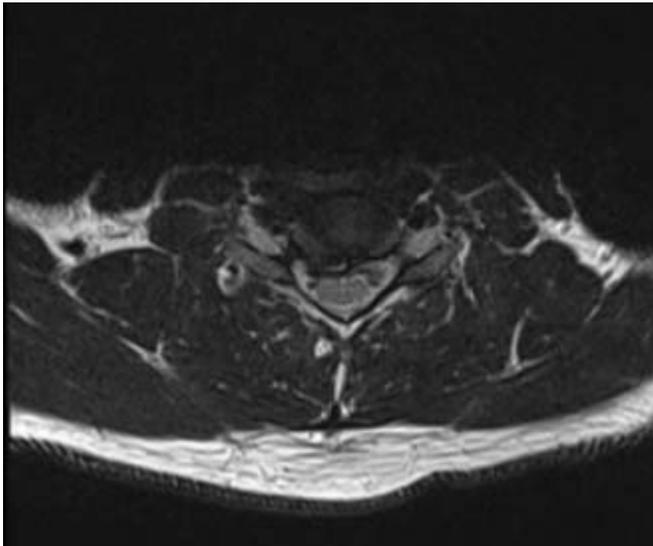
T2 weighted axial MRI
